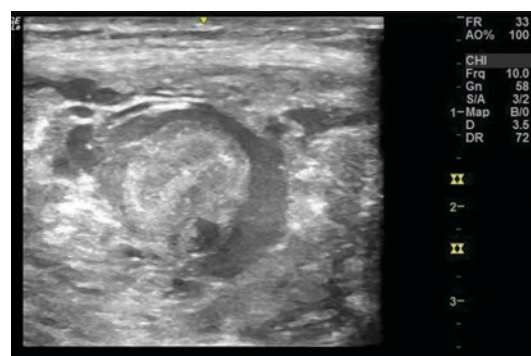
Short axis ultrasound rectus femoris intramuscular degloving
